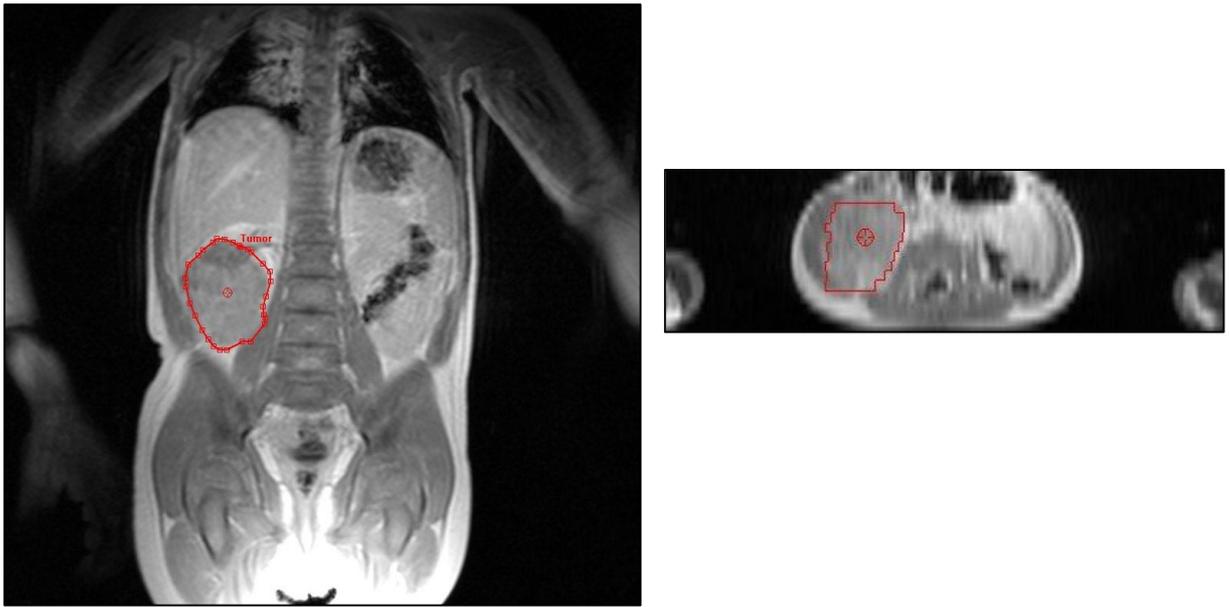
Contouring of tumours in MRI data sets.
